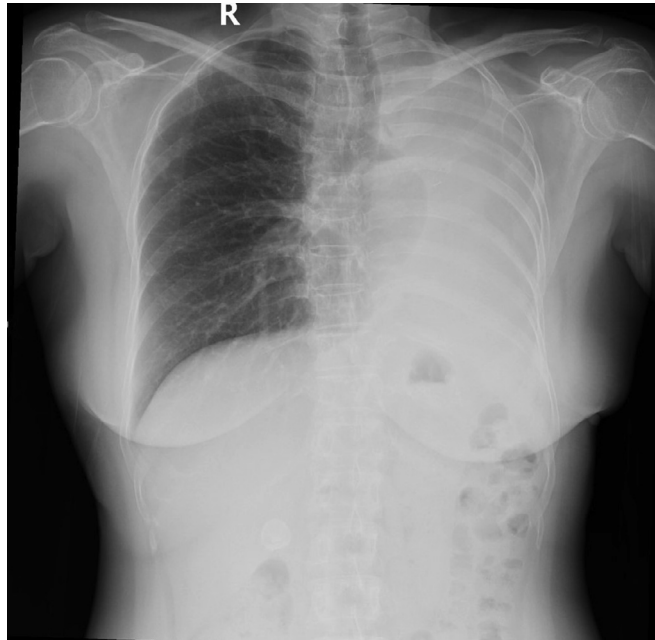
X-ray evaluation 9 months post thoracotomy.
